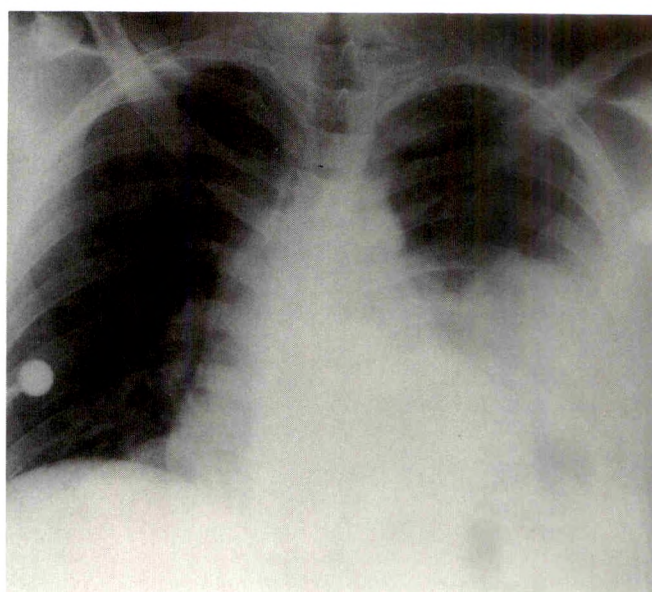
Chest radiograph shows marked apparent elevation of left hemidiaphragm with possible left lower lobe contusion or atelectasis. A moderate pleural effusion is present. Mediastinal shift to right is noted. An area of lucency is seen in lower left hemithorax. Surgery revealed a 10-cm tear of left hemidiaphragm with herniation of splenic flexure into left hemithorax.
